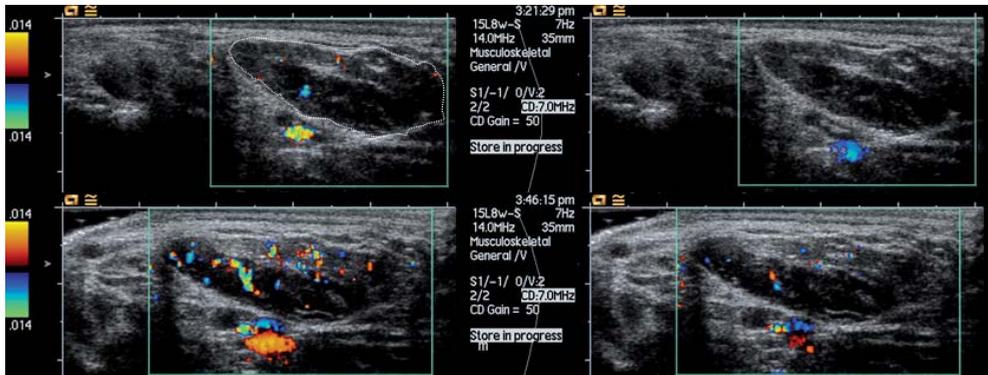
Color fraction before and after ischemia. The images are transverse scans of the left abductor hallucis muscle in a control subject. Top row shows the maximum and minimum color Doppler activity before ischemia. The muscle is outlined with a dotted trace and the color fraction (CF) is 3%. In the diastole there was no Doppler activity and the CF was 0%. The bottom row shows the corresponding findings after 2 minutes ischemia. The maximum CF (left) is 20% and the minimum CF (right) is 4%.
